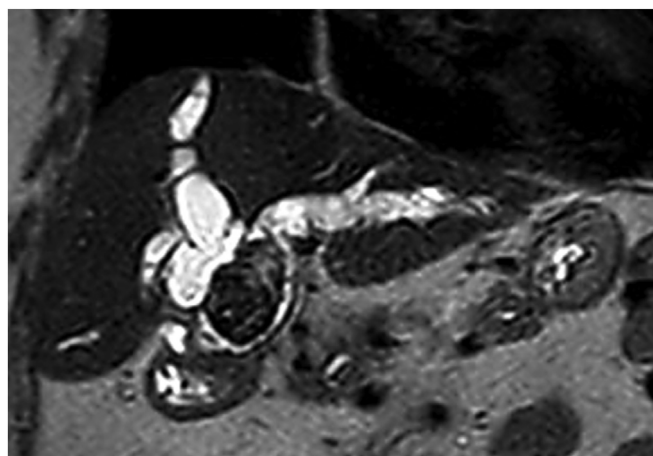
Giant intrahepatic stone. Magnetic resonance imaging showing biliary dilation and a 40-mm biliary stone above the hepatico-jejunostomy in a patient with Roux-en-Y reconstruction.
